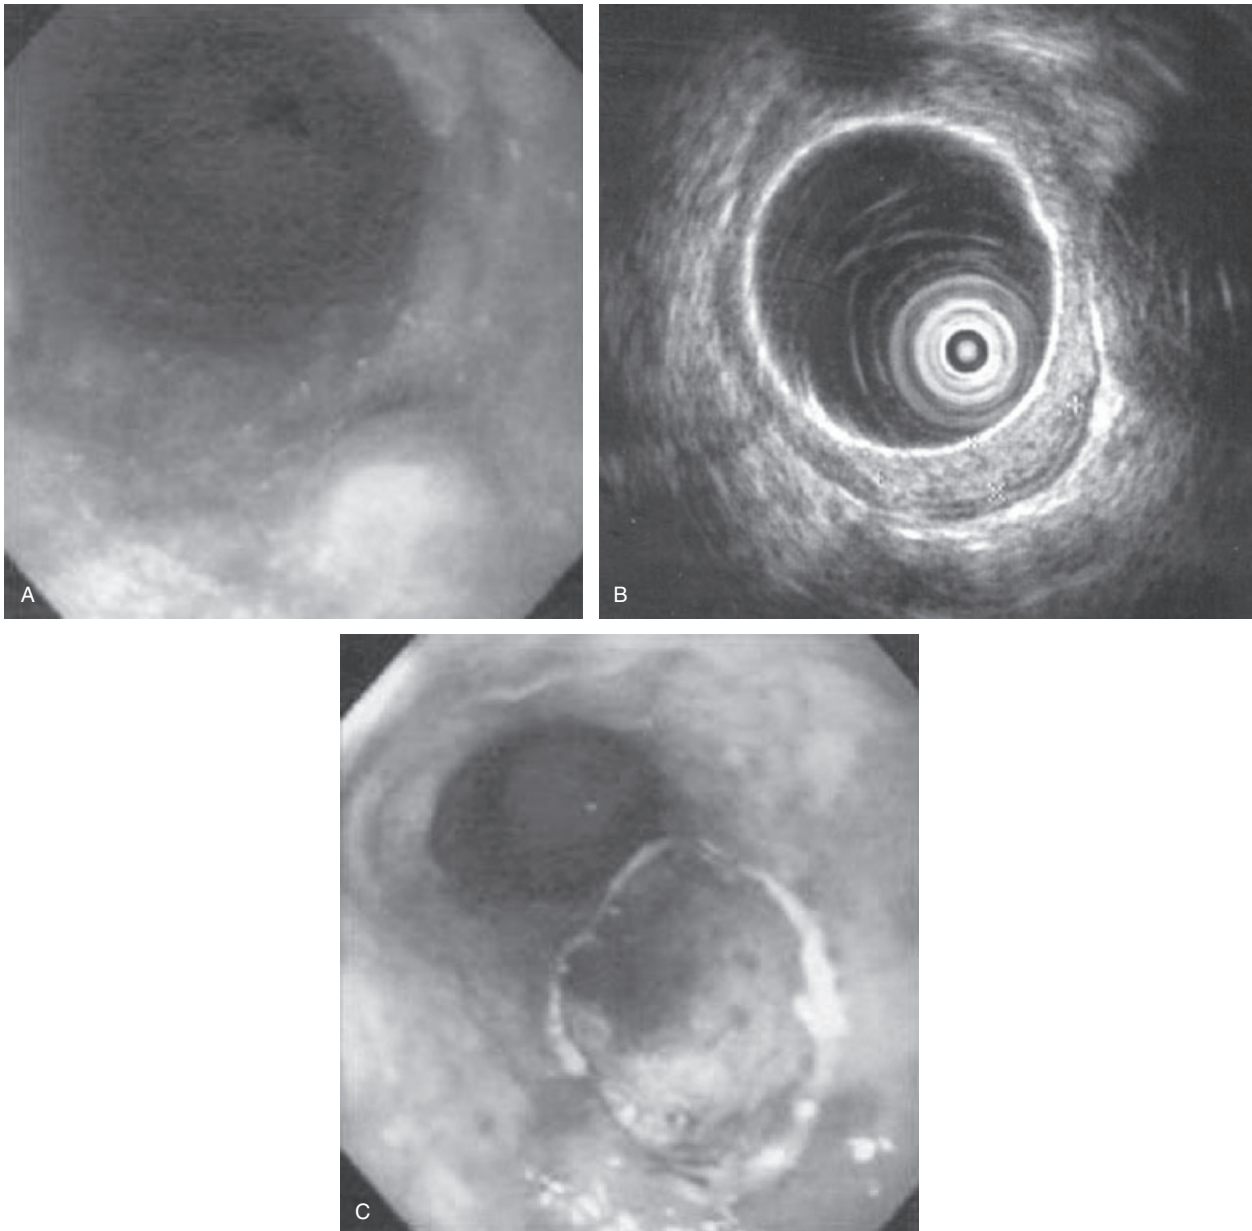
(A) Endoscopic picture showing esophageal nodule in the setting of Barrett's esophagus. (B) Endoscopic ultrasound image showing a mucosal hypoechoic lesion consistent with superficial esophageal tumor without invasion of submucosal layer. (C) Endoscopic image showing esophagus following endoscopic mucosal resection.
